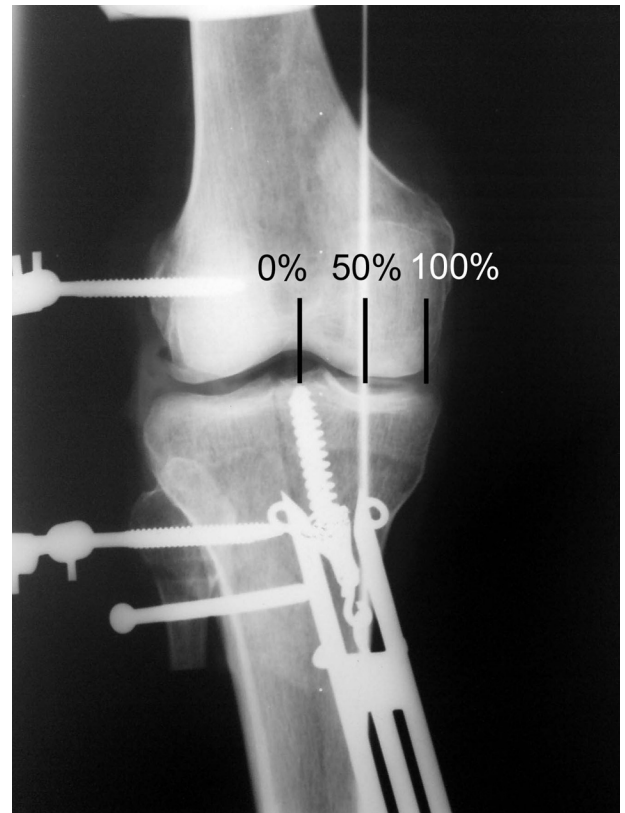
An AP radiograph of a knee with the anterior cruciate ligament bone plug, tensiometer, and lateral extensometer in place. The weightbearing line passed 50% as indicated by the metal wire.
